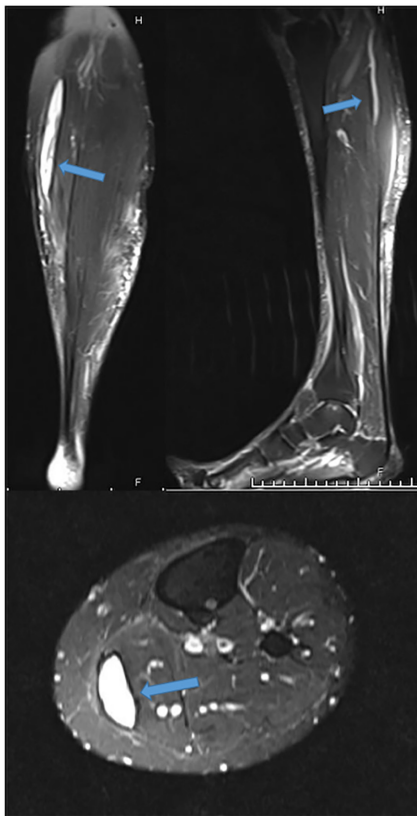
Magnetic resonance images of the left calf (a partial tear of the medial head of gastrocnemius muscle together with a hyperintense fluid collection between the medial head of the gastrocnemius and soleus on T2-weighted sequences) (up picture: coronal and sagittal images; down picture: axial image)
